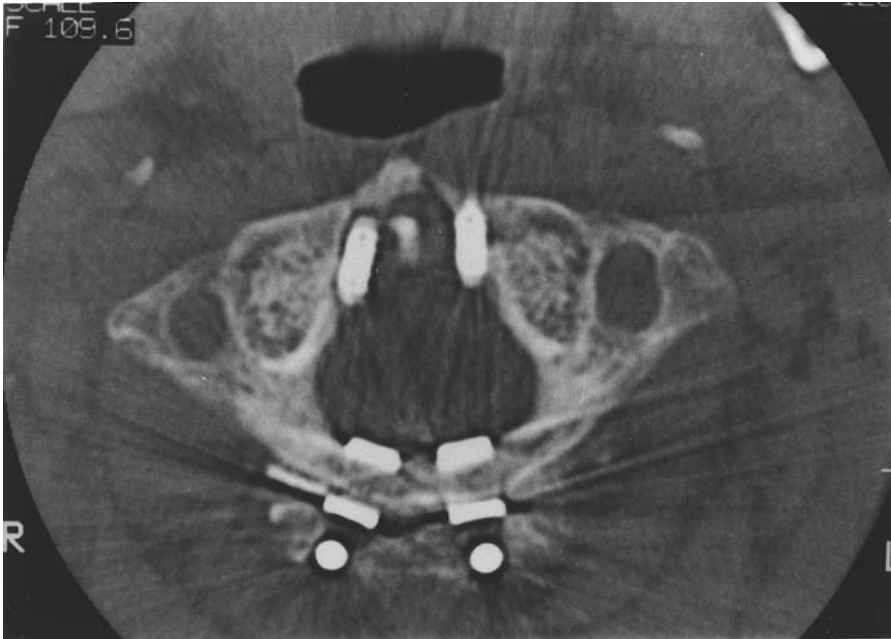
Case 35: A 69-year-old female, atlantoaxial subluxation associated with rheumatoid arthritis. The surgeon experienced massive venous bleeding during insertion of the left guidewire. He reinserted wires at medial direction. Postoperative CT scan, demonstrating the bilateral screws placed medially to the lateral mass of the atlas within the spinal canal.
